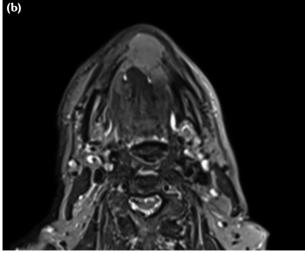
(a) Sagittal and (b) axial T1-weighted magnetic resonance imaging of the tumor located in anterior segment of mandible.
